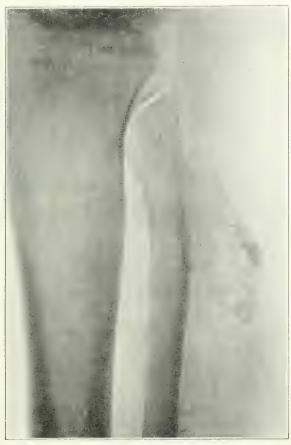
Pathological No. 16420. Benign exostosis of shaft of fibula, lateral view. X-ray by Dr. E. A. Smith, of Milwaukee. Tumor observed during convalescence from typhoid. X-ray taken three years after onset. No change in tumor three years later.
